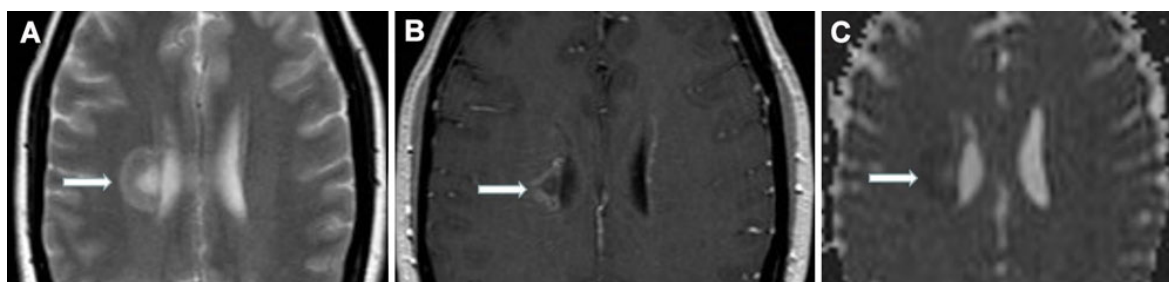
(A) Axial T2-weighted image reveals a high signal periventricular lesion; (B) axial T1-weighted image shows peripheral open ring enhancement after contrast administration; (C) apparent diffusion coefficient map shows restricted diffusion at the periphery of the lesion
